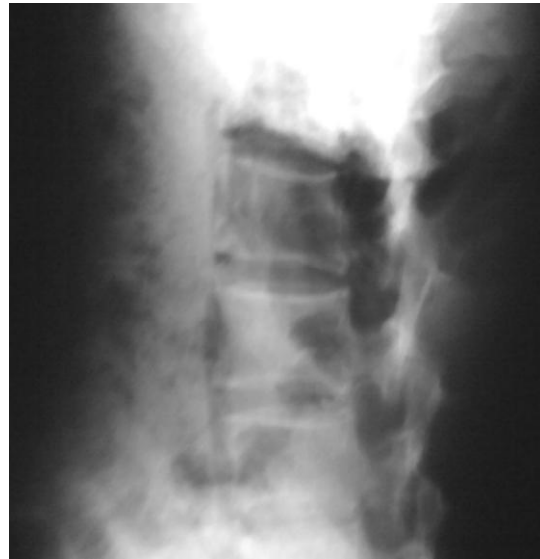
Plain abdominal roentgenogram showed diffuse subcutaneous emphysema.
